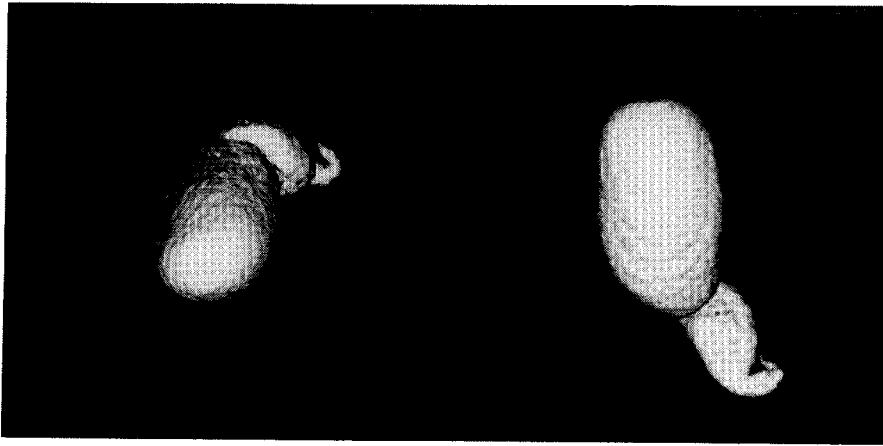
The three-dimensional CT images of the gallbladder of a volunteer using the surface rendering method 60 min after the beginning of billiscopin DIC® drip intravenous infusion. The volume of the gallbladder was measured to be 31.4 ml.
